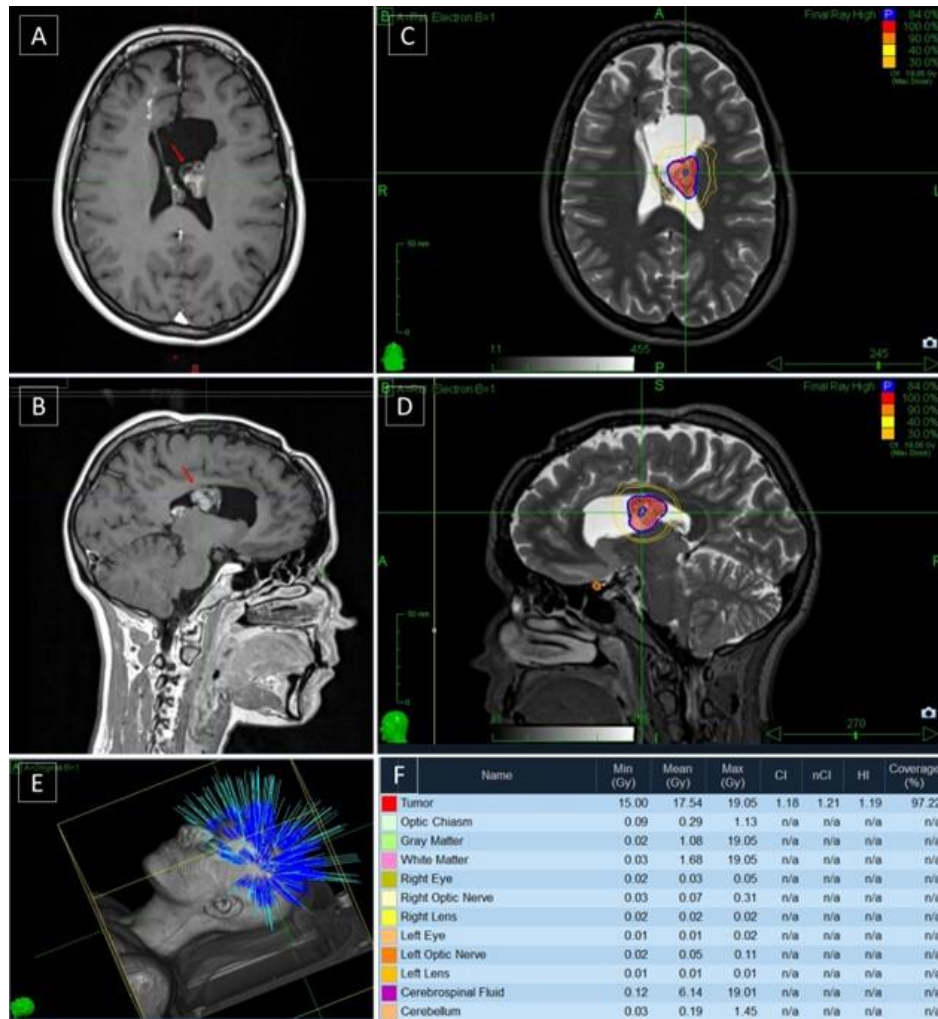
A and B - Axial and Sagittal MRI T1 sequence with gadolinium, respectively (the red arrow points to the CN location); C and D - Axial and Sagittal view of Cyberknife radiosurgery treatment planning and isodose curves; E - Cyberknife treatment beam geometry; F - Dose distribution at the Tumor and Organs at Risk. (Min - Minimum; Max - Maximum; CI - Conformity Index; nCI - Normalized Conformity Index; HI - Homogeneity Index; Gy - Gray).
